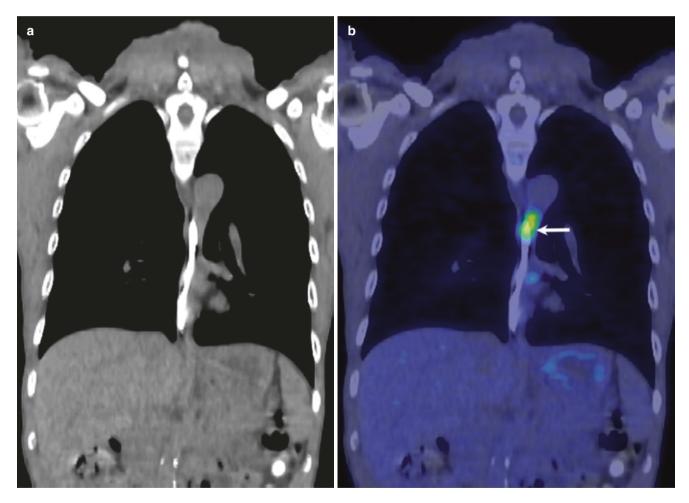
(a) Coronal CT and (b) fused PET-CT image shows primary mid-esophageal malignancy (arrow). (c) MIP images shows primary mid-esophageal malignancy with multiple distant lymph node metastases
